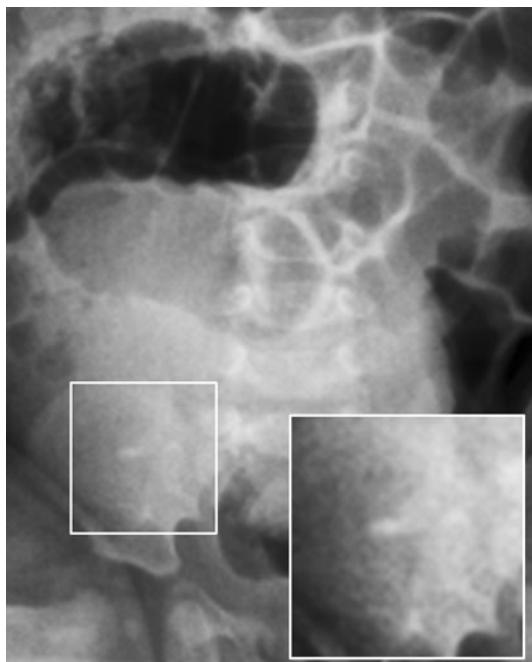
Plain abdominal radiograph
